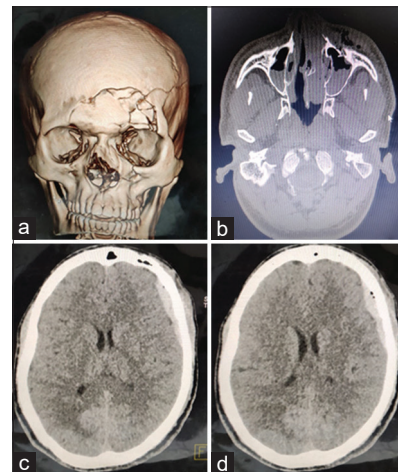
Case of self-fall. (a and b) 3D Reconstruction and axial section of CT, respectively, showing frontal bone, nasal bone and left infraorbital rim fracture. (c and d) Axial sections of CT showing EDH (Epidural Hematoma) and pneumocephalus noted in relation to left temporal region
